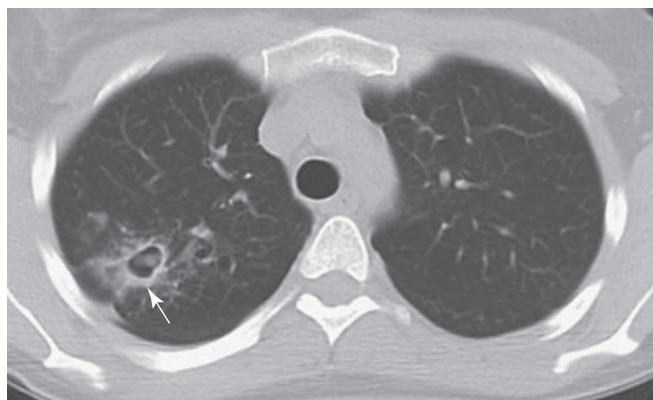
Representative CT image of the lungs of a 41-year-old woman who presented with stage V ABPA after a long history of mild asthma (IgE, 1500 IU/mL). Pulmonary function studies demonstrated severe combined obstructive and restrictive defects. CT shows bilateral upper lobe scarring and emphysematous changes.
